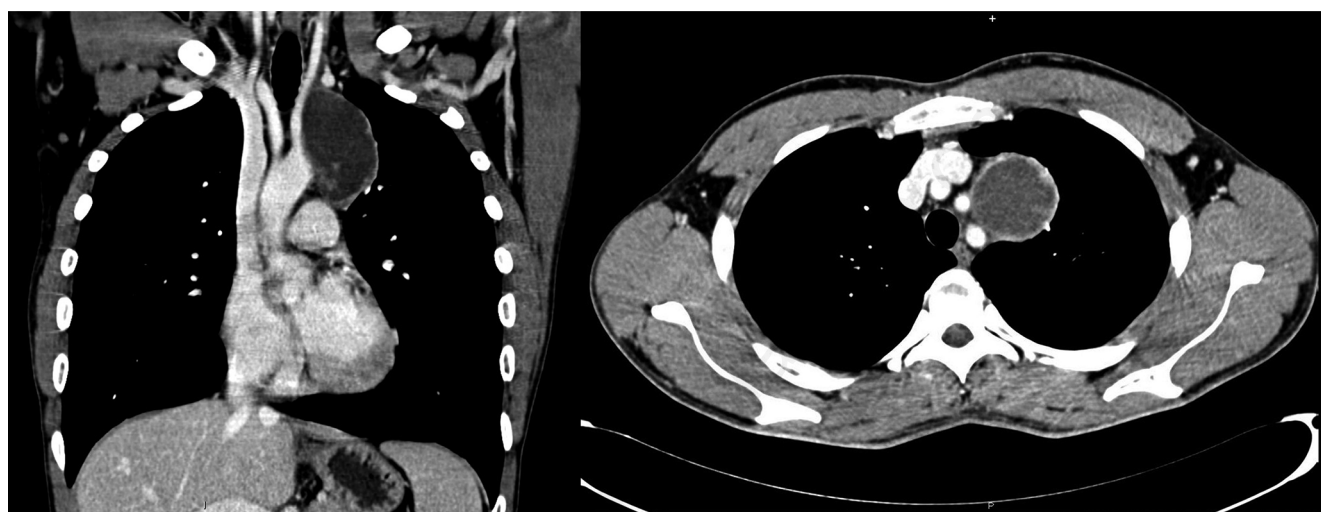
Computed tomography scan showing a well-defined, anterior mediastinal mass, with peripheral vascularization and some interior vascularized septa.
